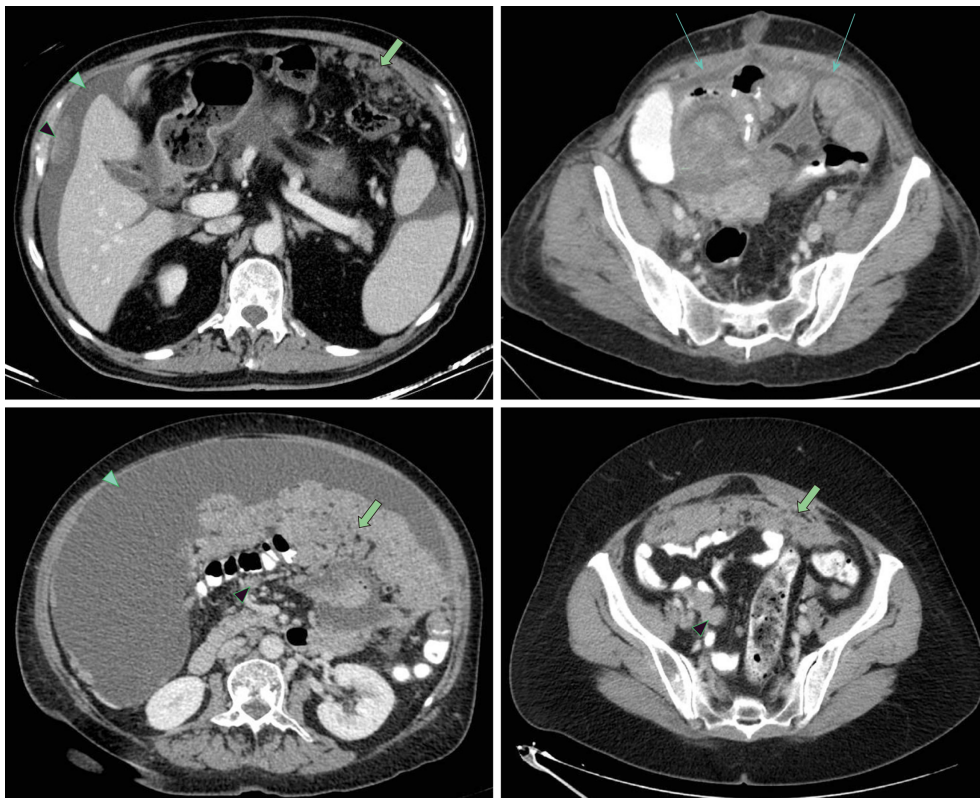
Radiological computed tomography signs for peritoneal disease. Wide green arrow: Omental cake; Thin green arrow: Peritoneal thickening; Green arrow-head: Malignant ascites; Black arrow-head: Peritoneal nodules.
